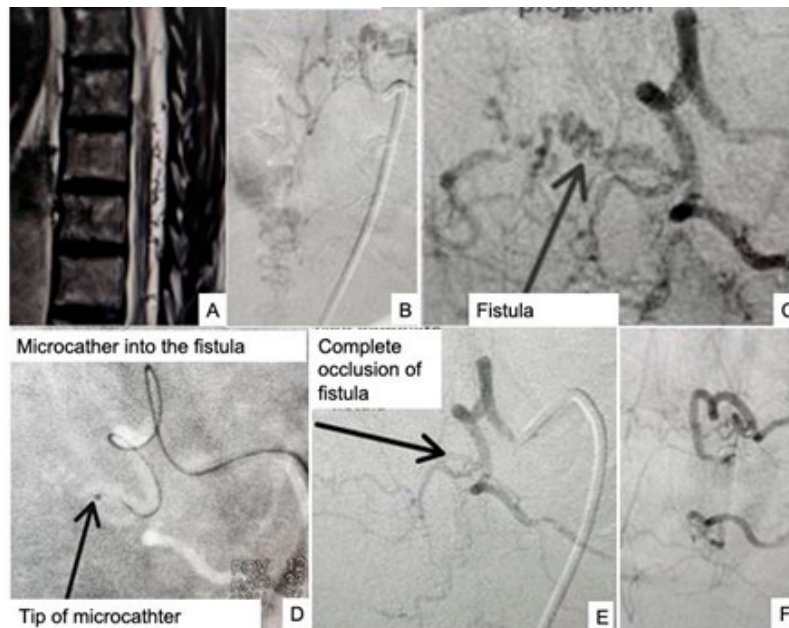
Endovascular closure of a dorsal spinal AVF. (A) MRI T2W image in sagittal view showing a suspected dorsal AVM. (B,C) Spinal DSA showing an AVF supplied by the left 8th intercostal artery; (D) road map microcatheter tip at the site of the fistula; (E) occlusion of the fistula; (F) DSA after occlusion of an AVF. Source: Figure by authors.
